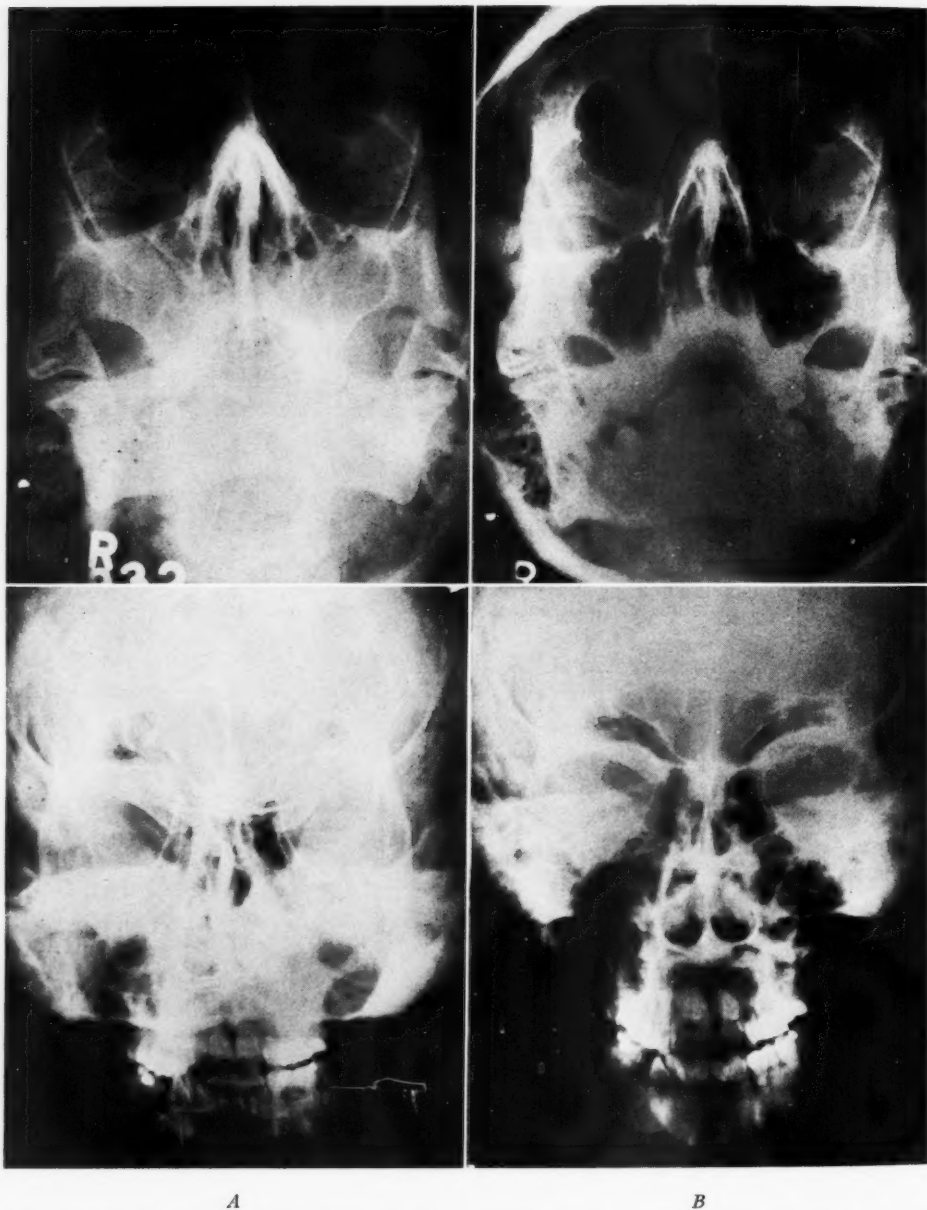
Mrs. L. W. M., white, aged 31 years, had sinus trouble "for years." Breathes through her mouth at night, expectorating large amounts of muco-purulent material on arising. Complained of cough, and pain over the antra. Roentgenograph "A" (Dec. 1, 1937) shows increased density of marked degree in both maxillary antra, with right ethmoid cloudy. After x-ray therapy (400 r), patient's headaches were completely relieved; cough and expectoration markedly diminished. Roentgenograph "B" (Jan. 3, 1938) shows all sinuses clear. In response to a questionnaire, patient reports she is now symptom-free for first time in many months.
